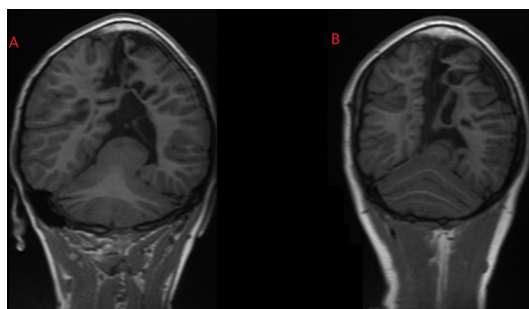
Coronal T1-weighted images confirm deficiency of the caudal vermis resulting in fusion of the cerebellar hemispheres (panel A). The cerebellar folia are noted to be horizontally oriented (panel B). Incidental note is also made of established bilateral parieto-occipital infarcts, the cause of which could not be identified.
